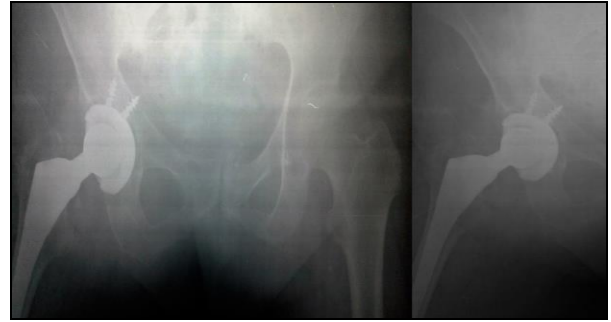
XRay rontgenogram showing cementless right total hip replacement.
